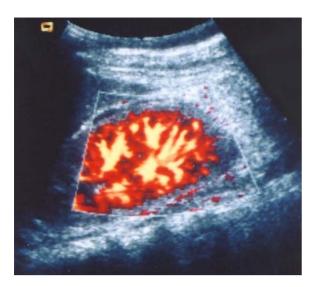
Amplitude-coded color Doppler sonography in glomerulonephritis ("halo"-sign"). Amplitude-coded color Doppler sonography demonstrates a small cortical peripheral rim- or halo-like layer with no color signals, indicating peripherally reduced flow (in spite of normal RI values) in a patient with glomerulonephritis
